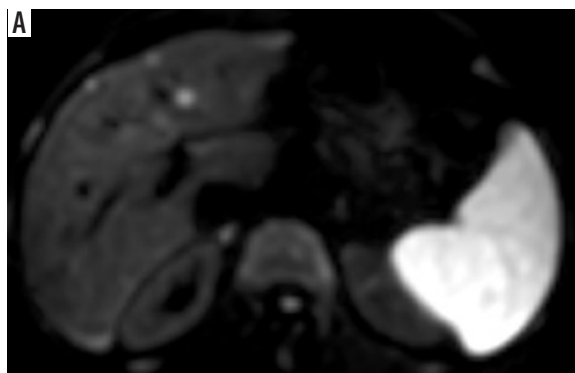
DWI (b value = $600 \text{ mm}^2/\text{s}$) and ADC map shows restricted diffusion with ADC value of hepatic focal lesion (1.31 and $1.38 \times 10^{-3} \text{ mm}^2/\text{s}$) by both reviewers, respectively
